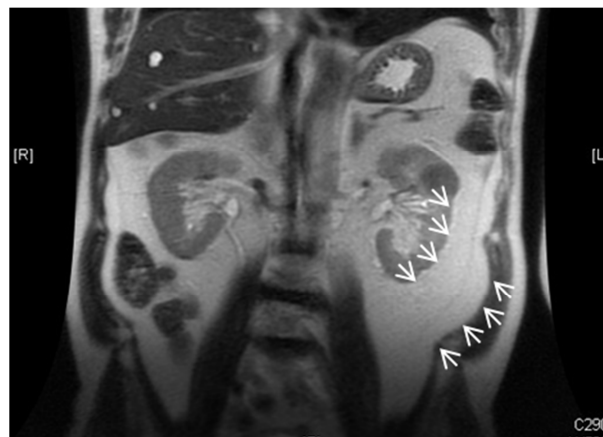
Coronal MRI of patient 5.03 (BMI 34kgm⁻²; clinically obese) demonstrating significant amount of peri-nephric fat (white arrow heads)
